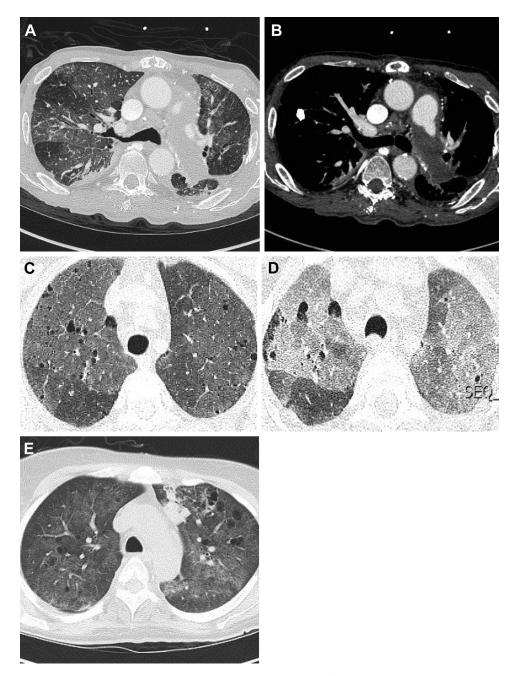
A,B, chronic thromboembolic pulmonary disease. CT images showing mosaic perfusion due to thrombus in the main pulmonary artery. C and D, Subacute hypersensitivity pneumonitis. C, Inspiratory films: low attenuation areas showing mosaic perfusion pattern. D, Expiratory film showing air trapping and accentuation of low perfusion areas. E, Pneumocystis jirovecii pneumonia: mosaic attenuation due to patchy ground glass opacities.
